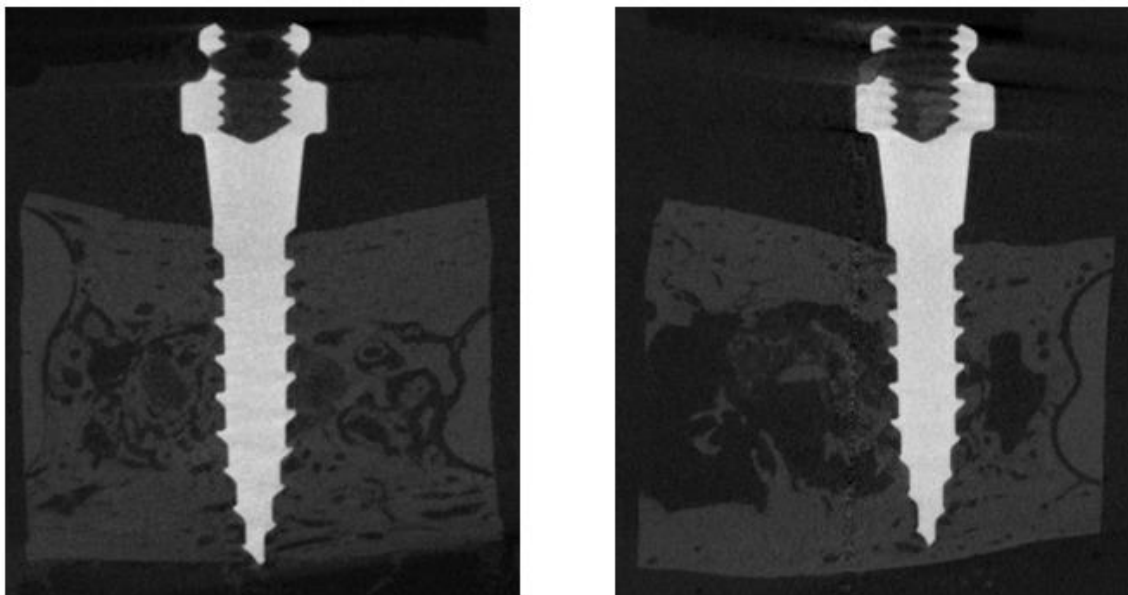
μ CT Analysis. Original gray-scale 2D cross section image showing MSI in center (white), surrounding bone (gray), and space (black). The buccal cortical bone is the side towards the head of the MSIs.
